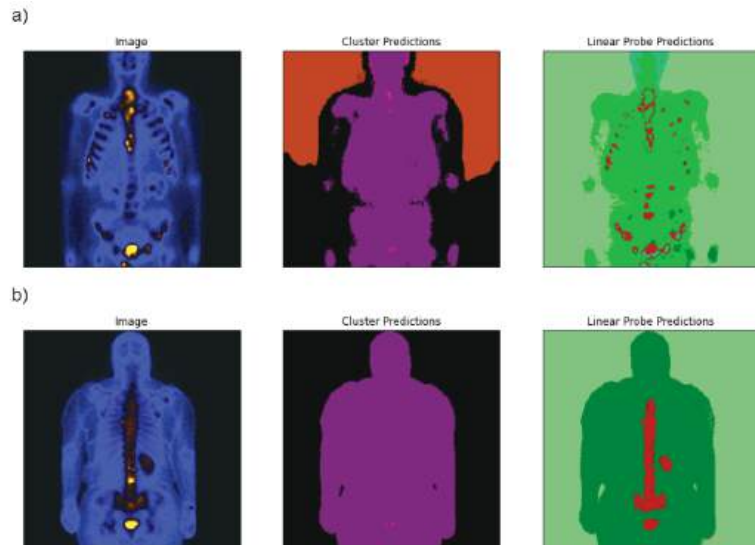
The initial scintigraphy image and STEGO outputs for patients with metastasis on the ribs (a) and on the spine (b).
